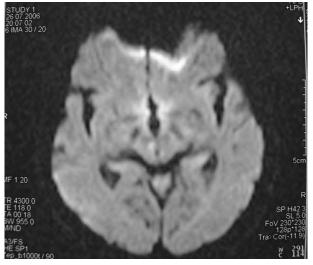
Diffusion weighted MRI of the Case 2 showed diffusion restriction in the left medial thalamus (a) and in the right mesencephalon (b).
